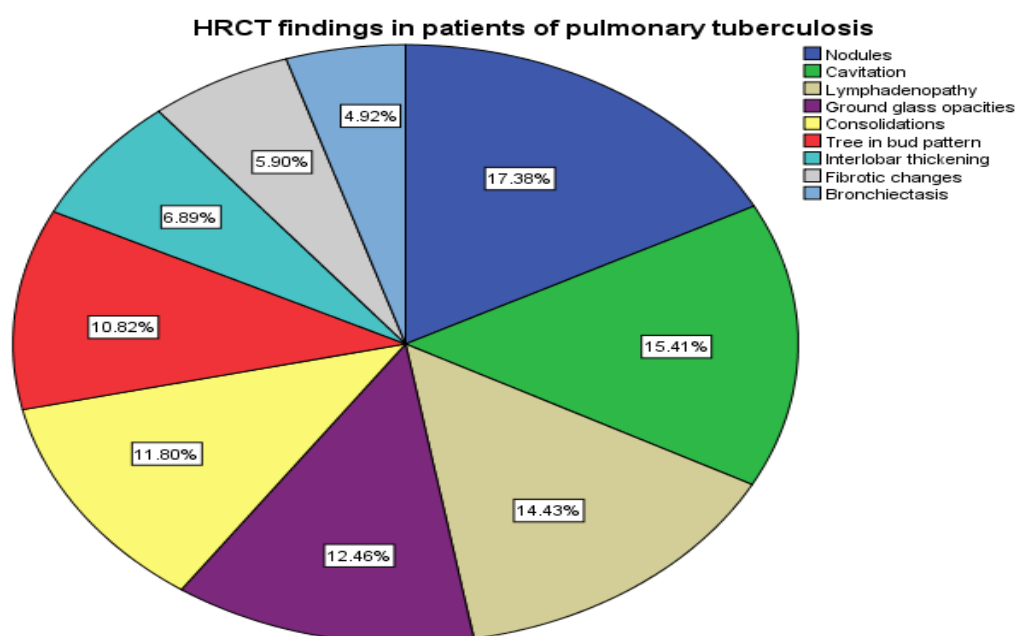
demonstrated the prevalence of the HRCT findings by the Pie chart. (N= 103)
